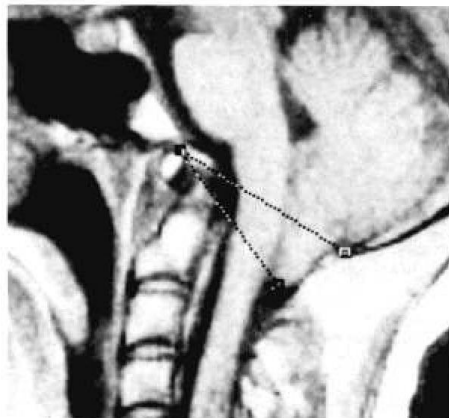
Midsagittal T1 MRI of the brain and cervical spine demonstrating cerebellar tonsillar herniation²⁴
